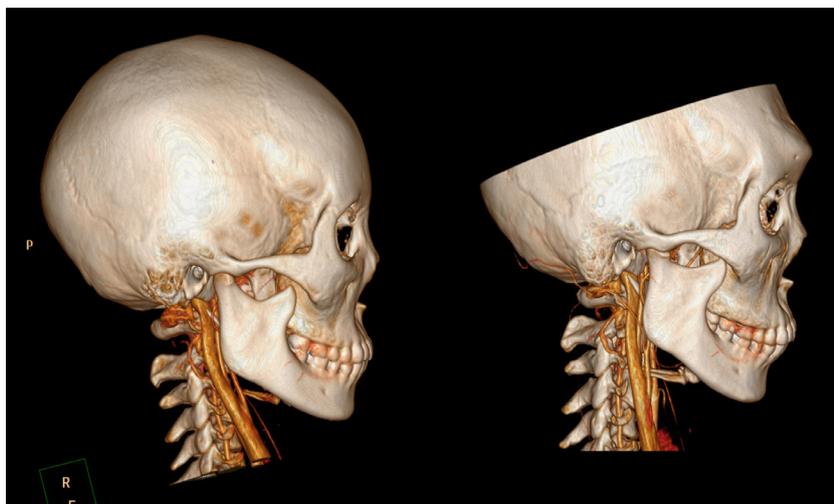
Computed tomography scans of the same patient pre- (left) and post-operatively (right) with a follow-up of 59 months.
